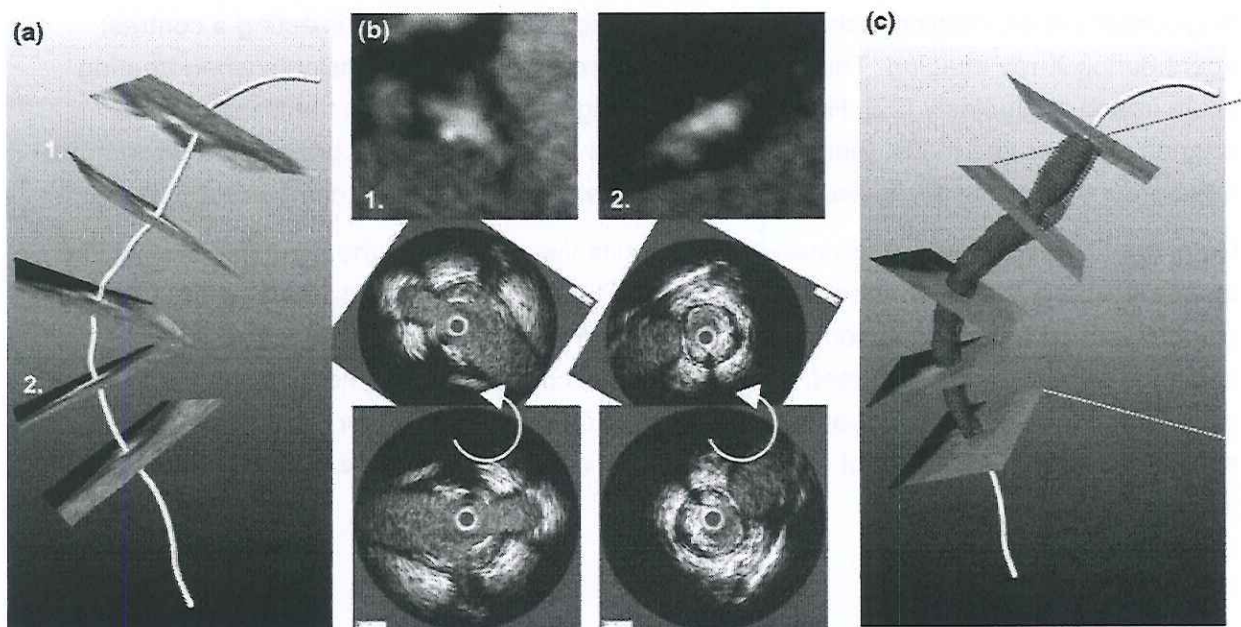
Fusion. The white line indicates the centerline (a) of the diseased artery obtained from CT. Perpendicular to the centerline are the IVUS images (b, 1 and 2). The CT images were matched to landmarks. Thereafter the 3D geometry (c) is obtained [26].
